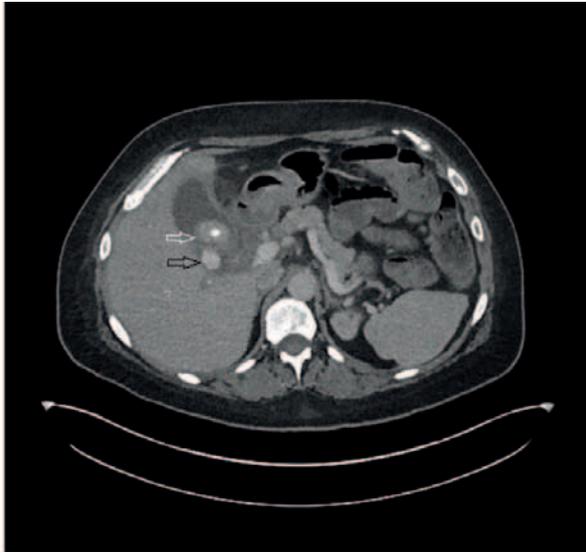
CT Angiogram, showing 3.8 cm right hepatic artery pseudo aneurysm (black arrow), surrounding haematoma and cholecystitis with impacted gall stone (white arrow).
